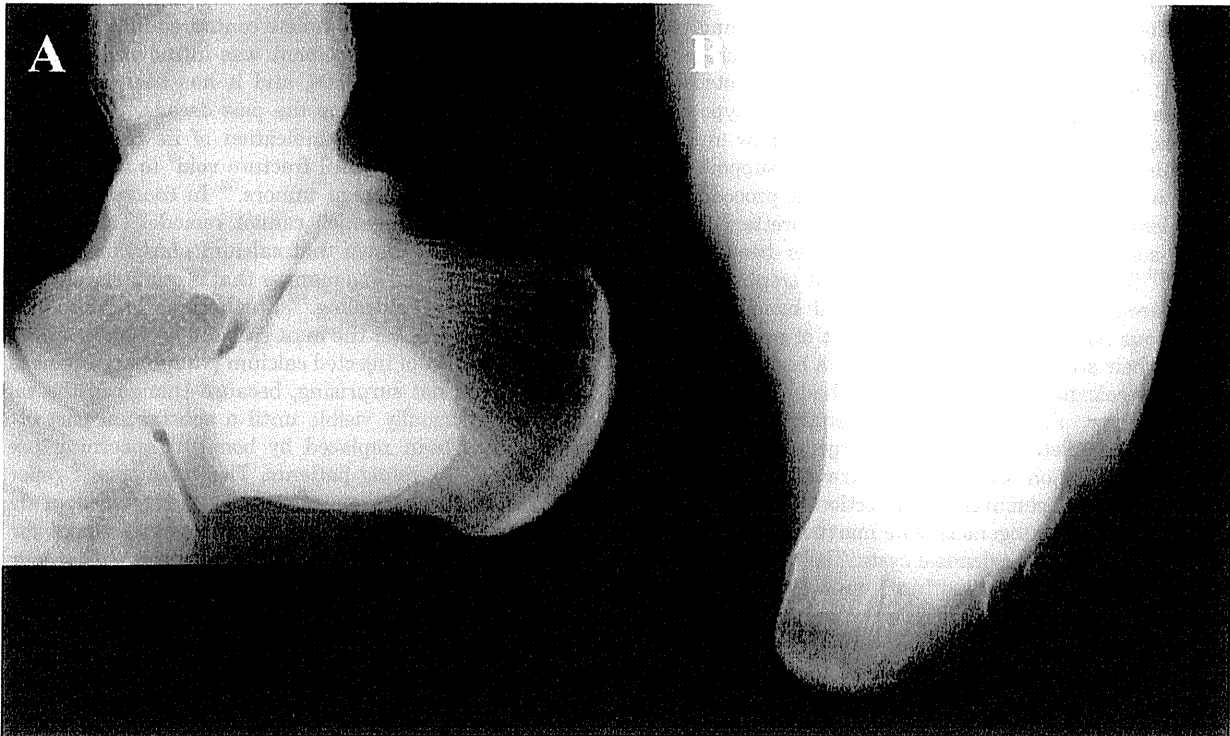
Lateral (A) and axial (B) radiographs of patient No. 4 at 40 months after surgery, showing neither pathologic fracture nor recurrence.
